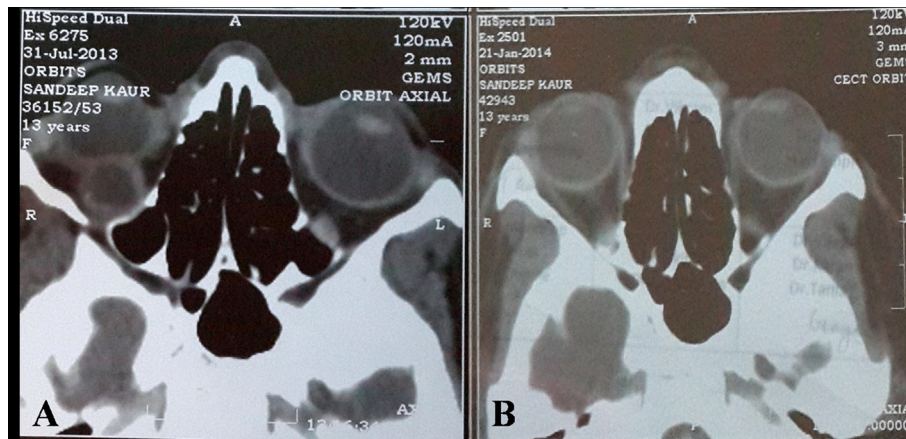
(A) CT scan shows bulky inferior rectus muscle with well defined cystic lesion with eccentric enhancing nodule. (B) CT scan done 6 months after treatment shows no cystic lesion or nodule or any new lesion.
